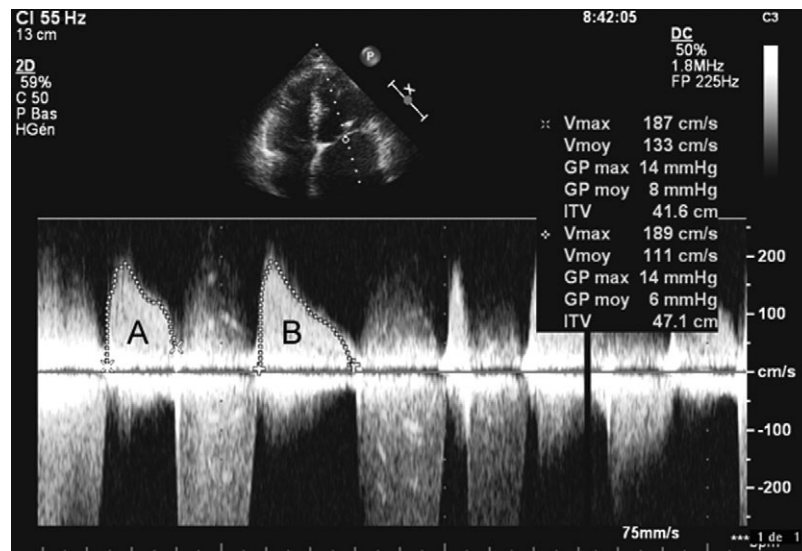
Determination of mean mitral gradient from Doppler diastolic mitral flow in a patient with severe mitral stenosis in atrial fibrillation. Mean gradient varies according to the length of diastole: it is 8 mmHg during a short diastole (A) and 6 mmHg during a longer diastole (B).
